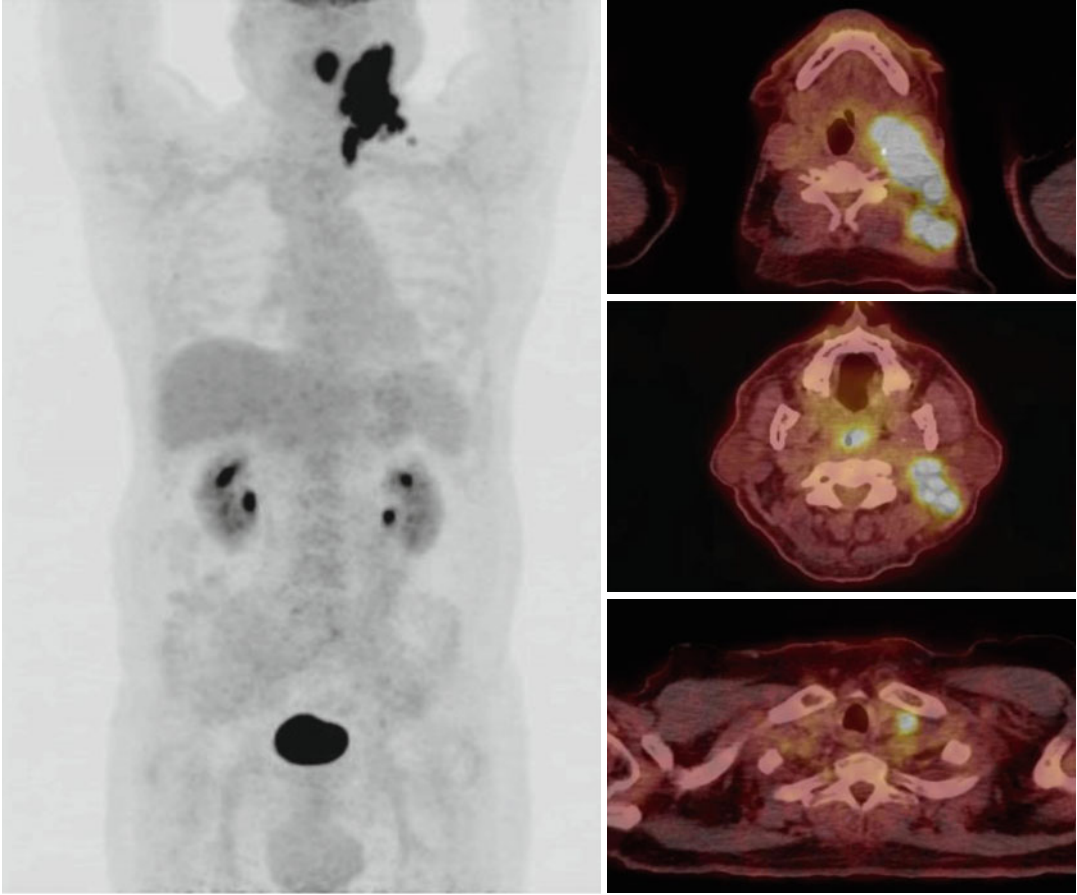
MIP-PET and fused PET/CT – initial staging: FDG PET shows increased metabolic activity in the pharynx, enlarged left-sided neck, supra- and infraclavicular lymph nodes
